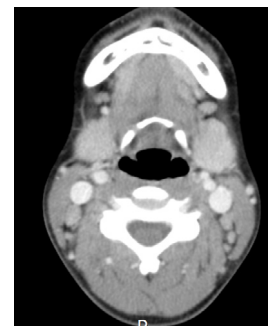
On neck computed tomography, multiple lymph nodes less than 2 cm-size in both cervical chain and supraclavicular area were observed.
